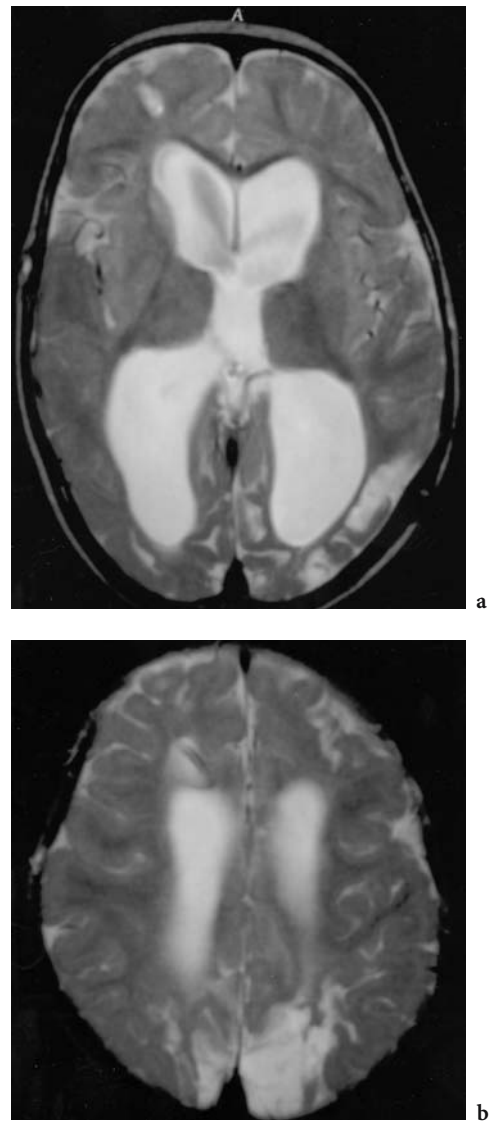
Axial T2-weighted FSE MRI of a 2-year-old boy with hydrocephalus. Shunt in right frontal horn. Bilateral occipital infarction following shunt dysfunction
